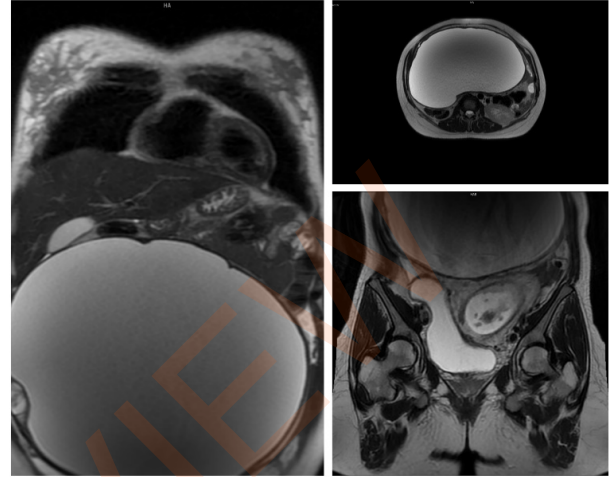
Preoperative Magnetic Resonance Imaging (MRI) Evaluation
